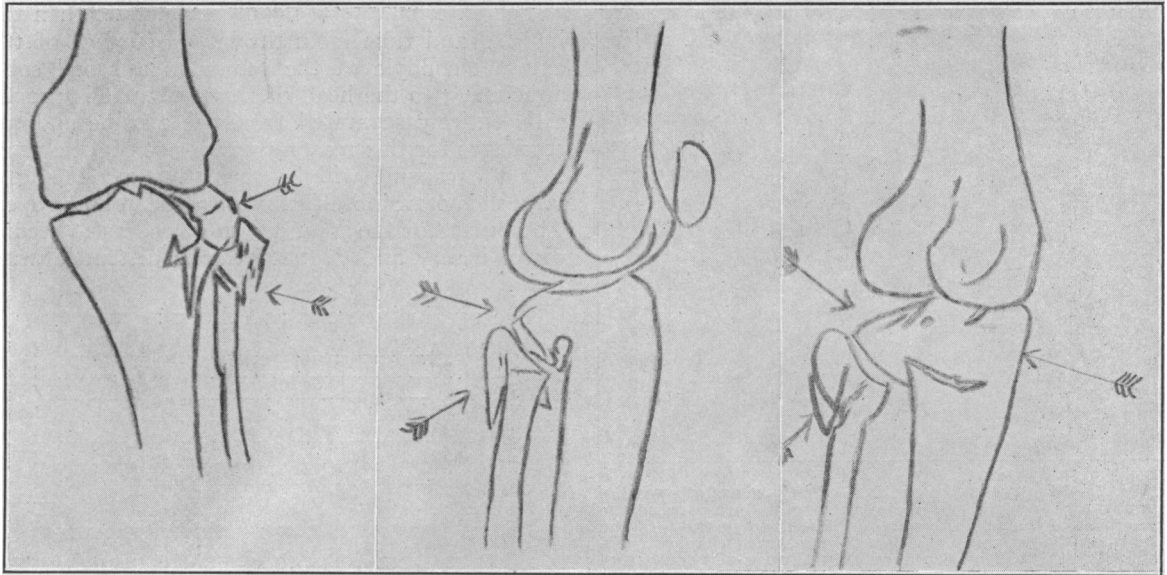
A tracing of an x-ray made in three positions of a typical bumper fracture of the knee, showing all of the factors outlined, and observed forty-five times in almost typical duplication in a series of knee joint injuries.
